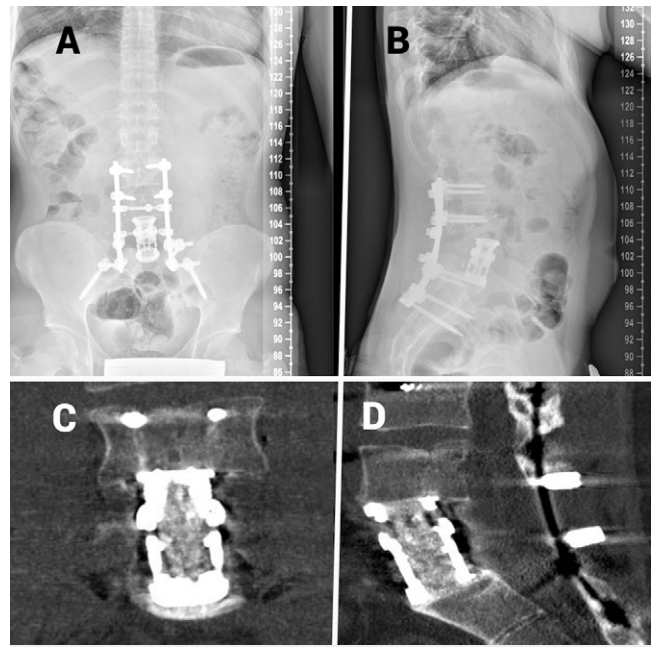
Anteroposterior (A) and lateral (B) views of a telemetry 9 years after surgery, with no signs of implant release. Coronal (C) and sagittal (D) reconstructed CT scans obtained 6 years after surgery, showing placement of the interbody cage, pedicle screws, and rods with no signs of instability and good alignment in the sagittal plane.
